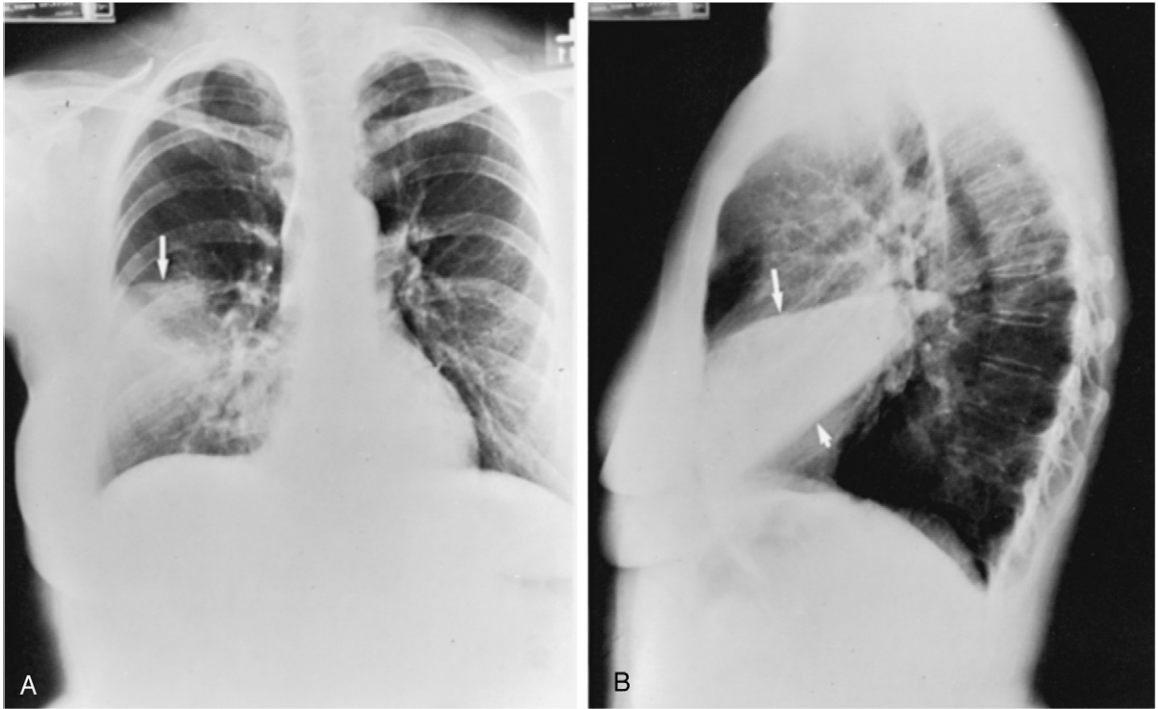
Posteroanterior (A) and lateral (B) chest radiographs show lobar pneumonia (probably caused by *Streptococcus pneumoniae*) affecting the right middle lobe. In A, arrow points to the minor fissure, which defines the upper border of the middle lobe. In B, long arrow points to the minor fissure, and short arrow points to the major fissure.
